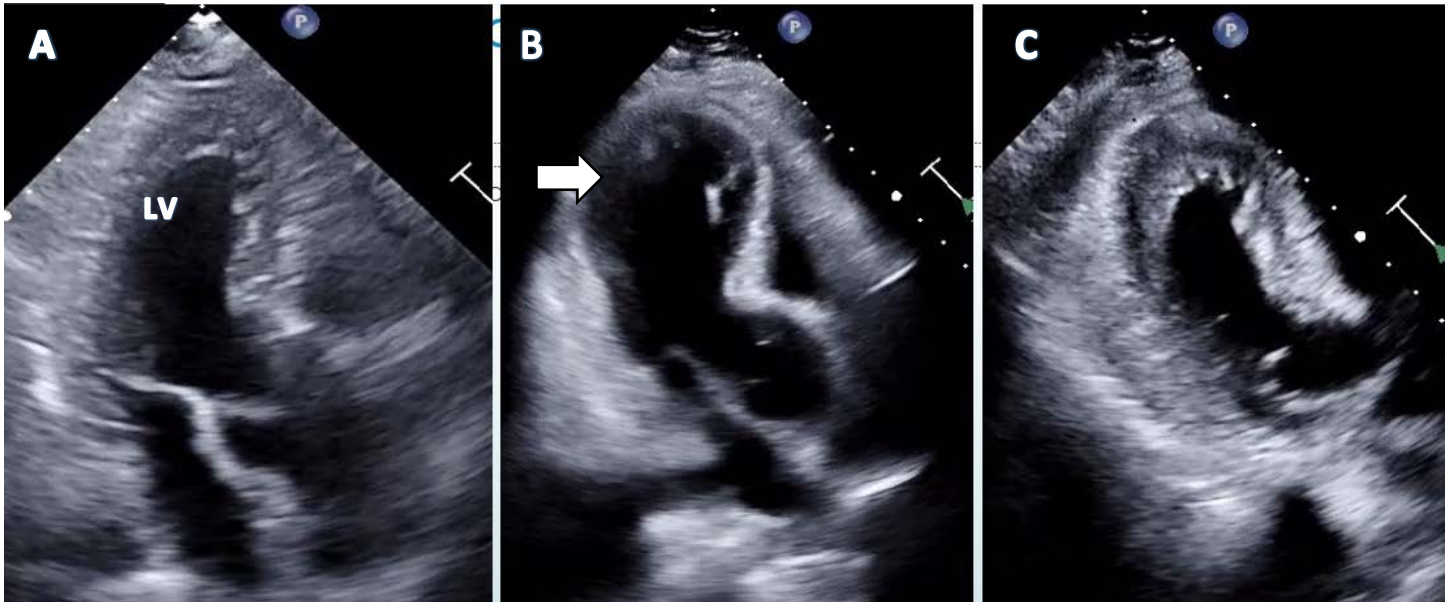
Comparison of serial transthoracic echocardiogram apical long-axis views for the patient in this case report, where Figure 1A is taken on day 1 of hospitalization, prior to the patient developing Takotsubo cardiomyopathy. The left ventricle is denoted by “LV”. Figure 1B is taken on day 4 of hospitalization which is when this patient is presumed to have developed Takotsubo cardiomyopathy; note the marked apical ballooning of the left ventricular cavity (white arrow). Figure 1C is taken on day 8 of hospitalization; note the significant improvement in apical ballooning of the left ventricular cavity compared to Figure 1B. Each figure's image is taken at a similar phase during the cardiac cycle at the beginning of systole.
